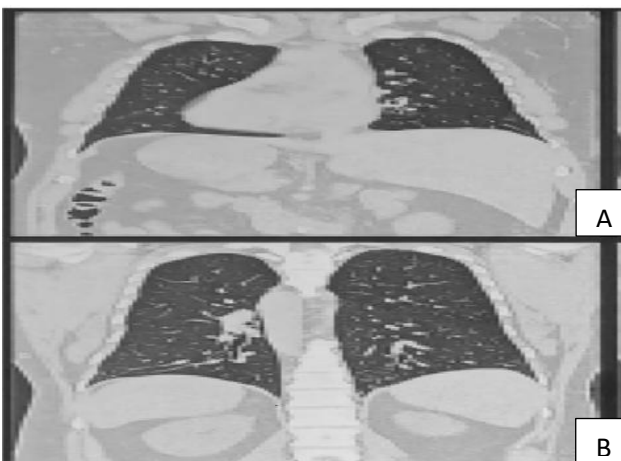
(A and B): HRCT thorax showing situs inversus totalis with bronchiectasis pattern in bilateral lungs.
